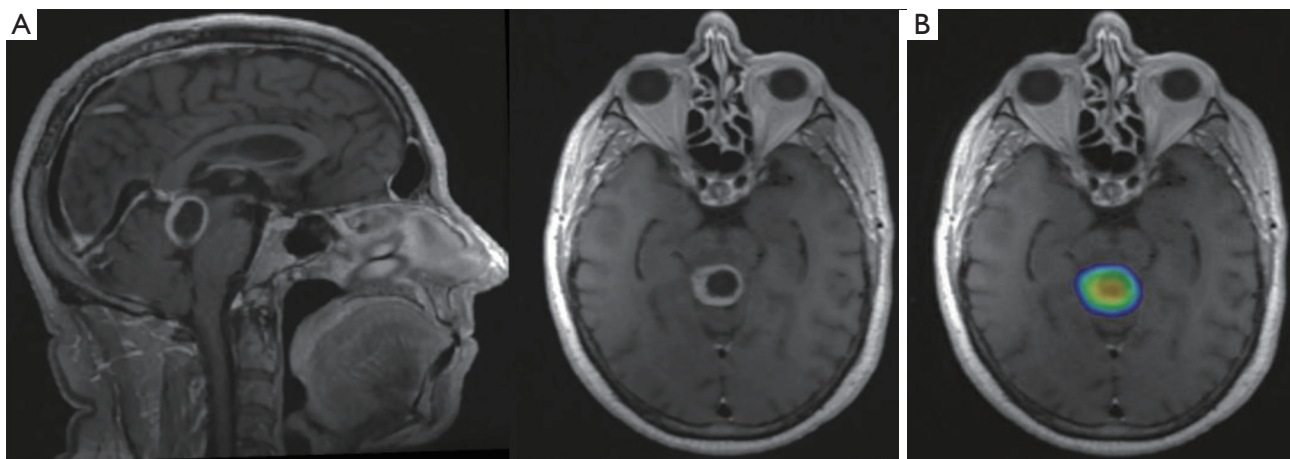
T1-weighted MRI images of metastasis in close proximity to midbrain and pons. (A) Sagittal and axial images of patient with melanoma metastatic to the cerebral aqueduct posterior to the midbrain and pons. (B) This lesion was treated with 27 Gy in 3 fractions of linear accelerator-based radiosurgery. MRI, magnetic resonance imaging.
